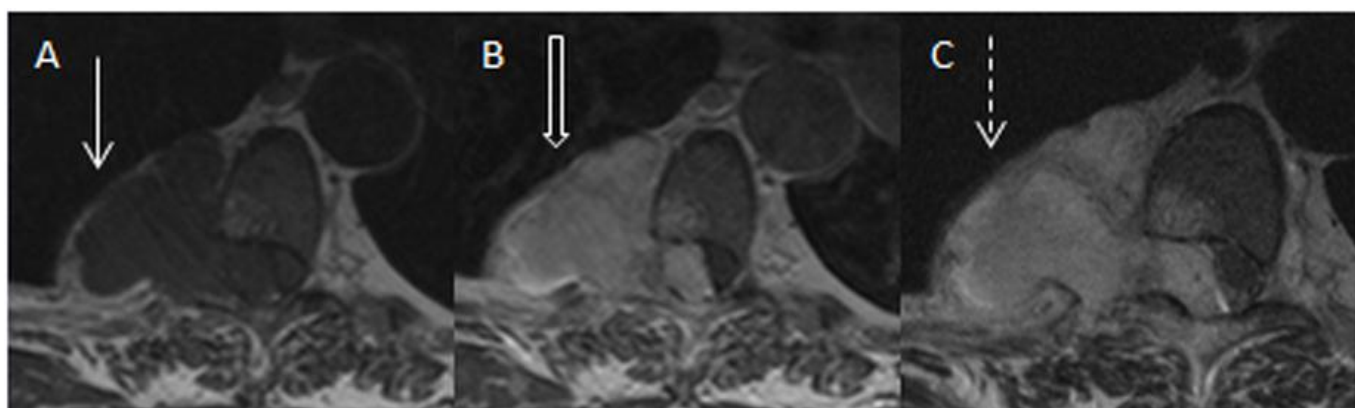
MR appearances of an angioliipoma in a 71 year old female. 4A) Axial image from T1-weighted spin echo sequences (TR 591, TE 17, 4mm slice thickness, FoV 512 x 512) through the thoracic spine revealing a dumbbell shaped lesion which is isointense to muscle and expands the neural foramen (solid white arrow). 4B) Axial image from post- gadolinium T1-weighted spin echo sequence (TR 591, TE 17, 4mm slice thickness, FoV 512 x 512, 15ml Dotarem contrast medium) revealing avid but heterogeneous enhancement (hollow white arrow). 4C) Axial image from T2-weighted turbo spin echo sequences revealing the tumour is of intermediate intensity (TR 5060, TE 99, 4mm slice thickness, FoV 408 x 512) (dotted white arrow).
